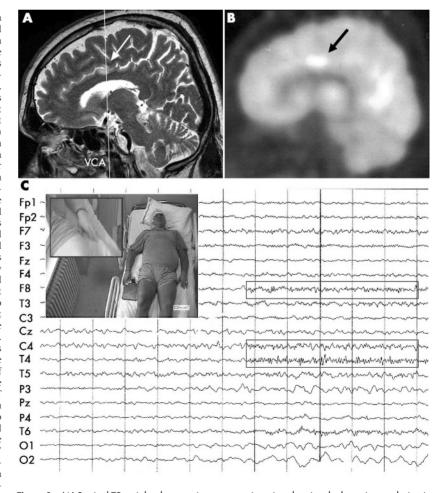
(A) Sagittal T2 weighted magnetic resonance imaging showing the hyperintense lesion in the rostral cingulate motor area (CMA) (day 4); VCA, vertical plane passing through the anterior commissure. (B) FDG-PET scan. (C) Video-EEG trace (ictal pattern (spiking) in the right F-C-T region time locked with an alien hand episode).
